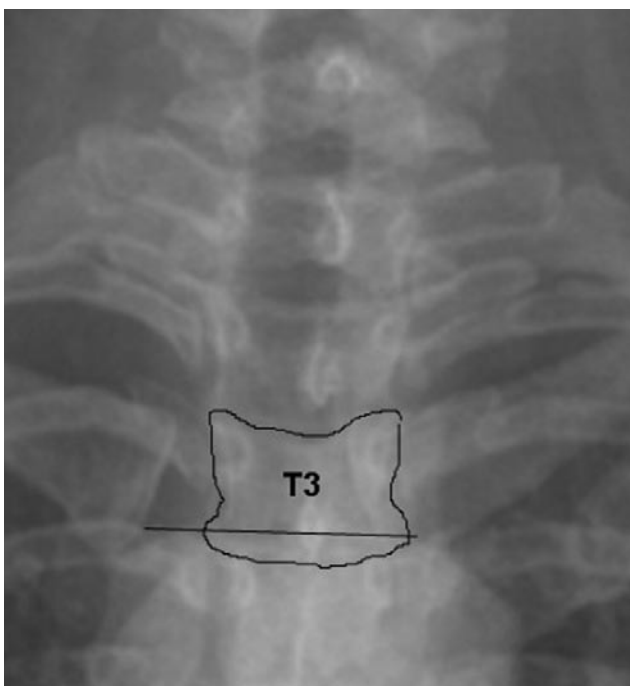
Anteroposterior radiograph shows biconvex line at lower fifth of medial end intersecting T3 body.
